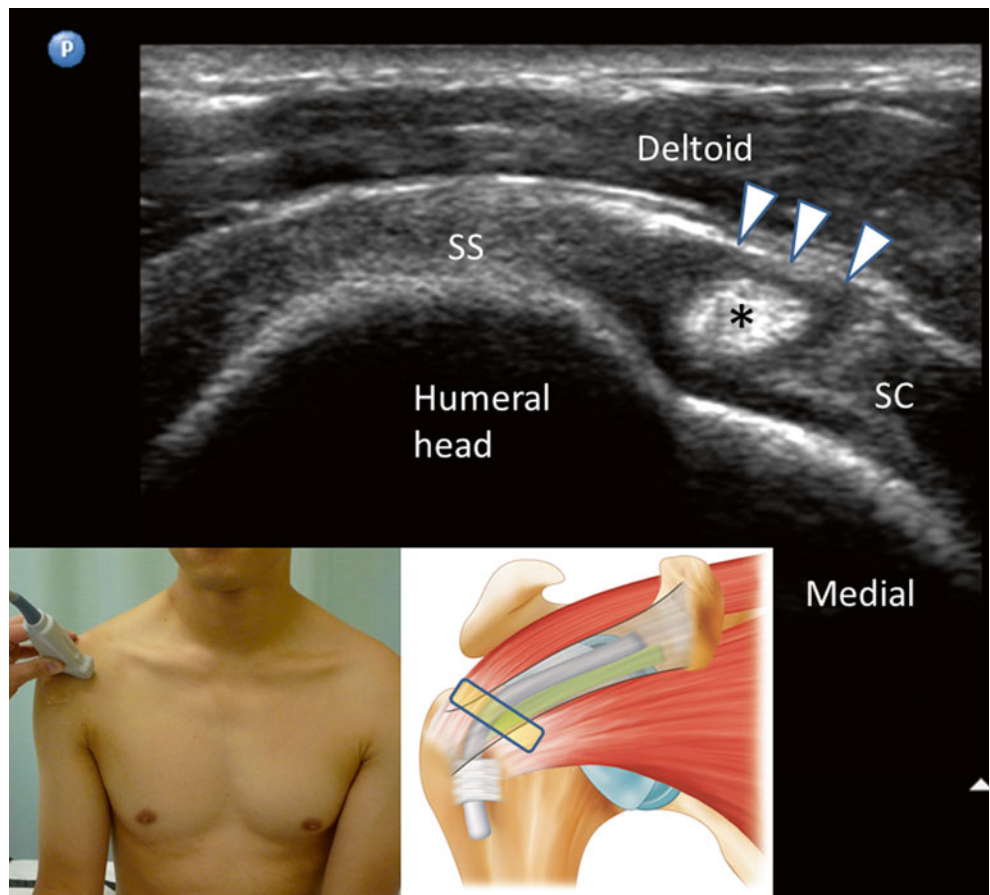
Ultrasound image showing the presence of long head of bicep (LHB) tendon (*asterisk*) within the rotator cuff interval. This image is obtained by moving the ultrasound probe proximal to the bicipital groove along the orientation of the LGB tendon. The LHB tendon (*asterisk*) is always hyperechoic at this level and sandwiched between the supraspinatus tendon (SS) laterally and subscapularis tendon (SC) medially. The coracohumeral ligament (*arrow heads*) forms the roof of the interval. The insert on the left shows the orientation and position of the probe, and the insert on the right shows the probe position and the structures underneath it (Reproduced with permission from Philip Peng Educational Series)
